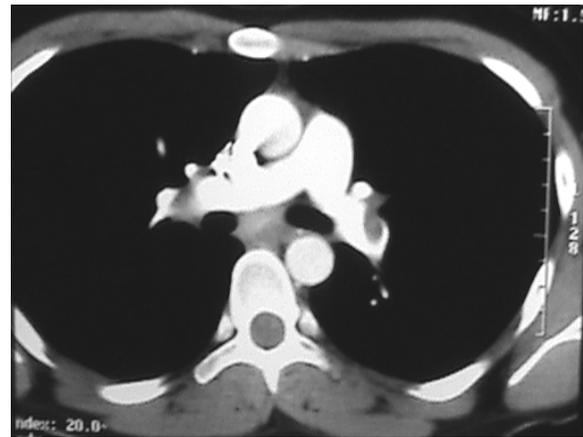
CT pulmonary angiogram showing bilateral thrombus formation in the distal parts of right and left pulmonary arteries
